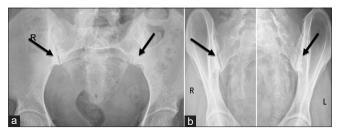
Conventional radiograph of sacroiliac joints in 40-yearold female who presented with inflammatory back pain for 8 years, showing bilateral Grade 3 sacroiliitis (arrows) (a) anteroposterior view (b) oblique view.
